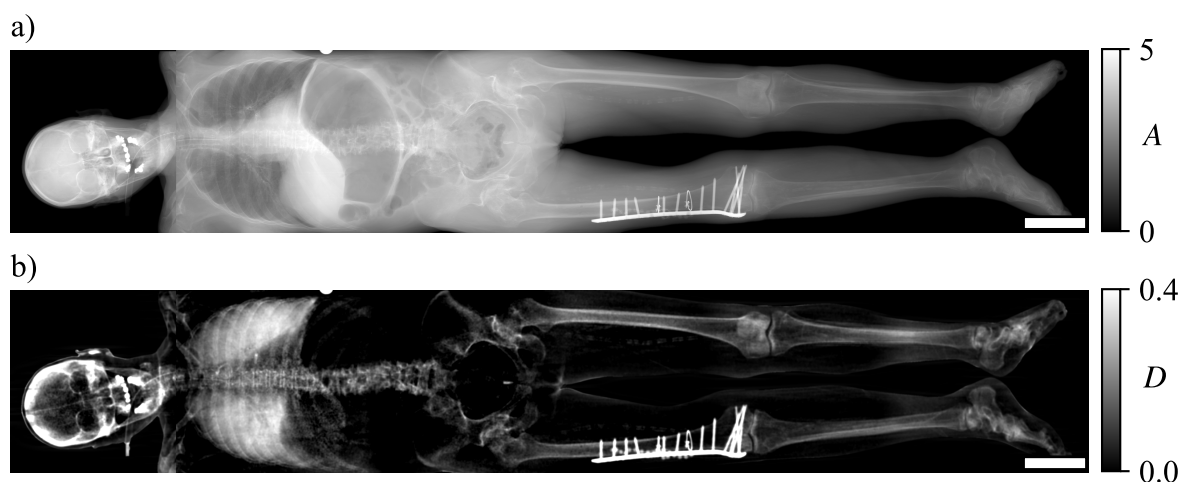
Attenuation (a) and dark-field (b) radiographs of the human body excluding the arms. The scale bar in the lower right corner has the size $10\text{ cm} \times 2\text{ cm}$. Images were taken in recumbent anteroposterior position with the right side of the body displayed on the left side of the image. A correction for beam hardening effects on the dark-field images was applied.
